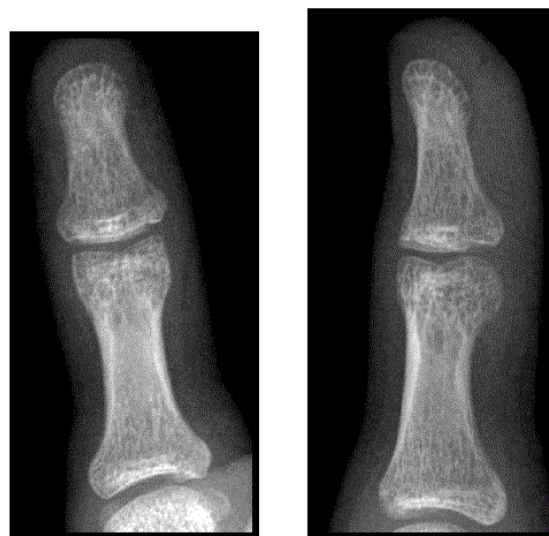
X-ray image after K-wire removal. It shows consolidated fracture 6 weeks after the injury.
